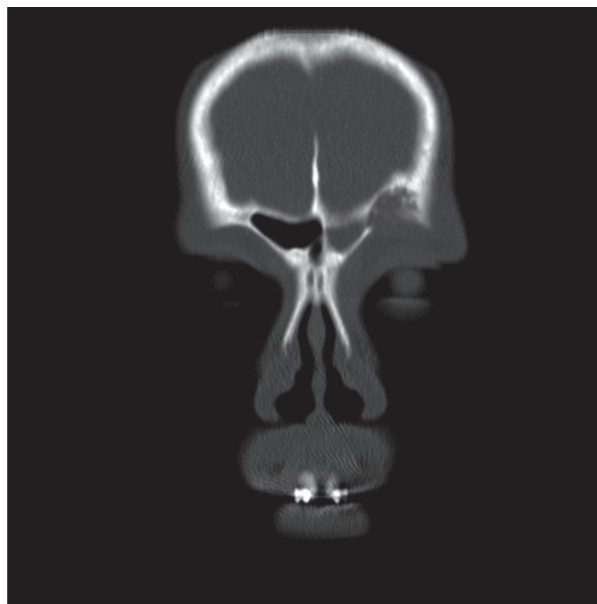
Coronal view of CT of the head showing left frontal sinusitis with superior orbital extension and bony erosion
